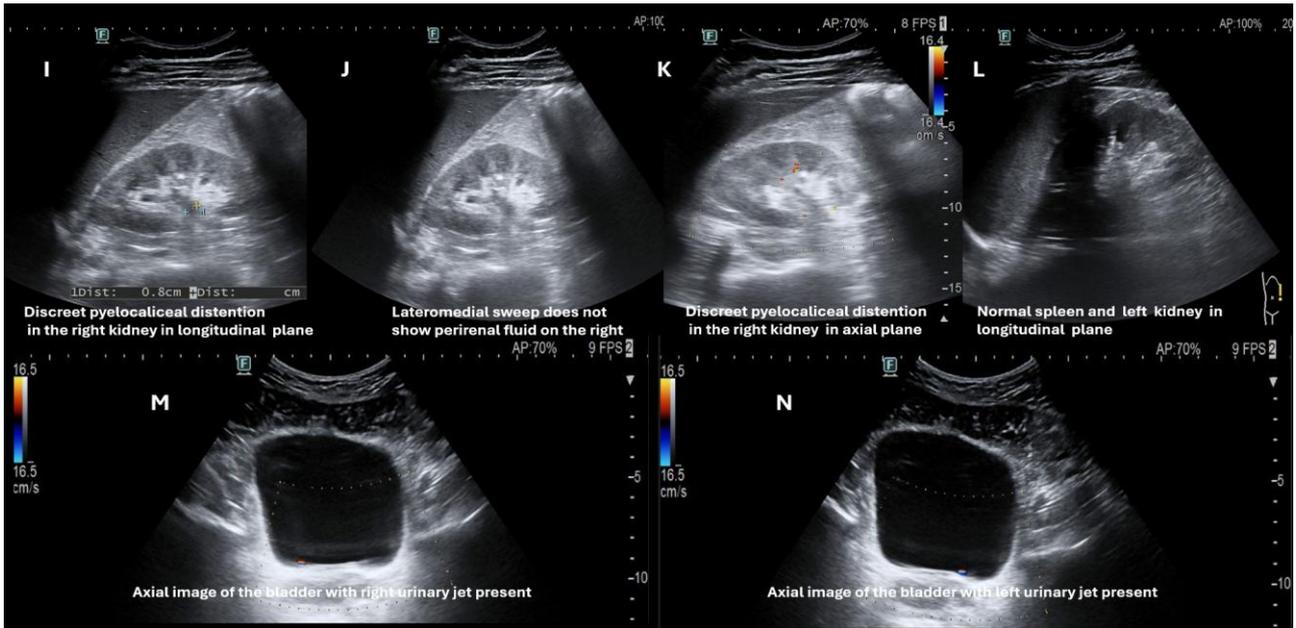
Represents 6 images belonging to the first renal screening ultrasound.
